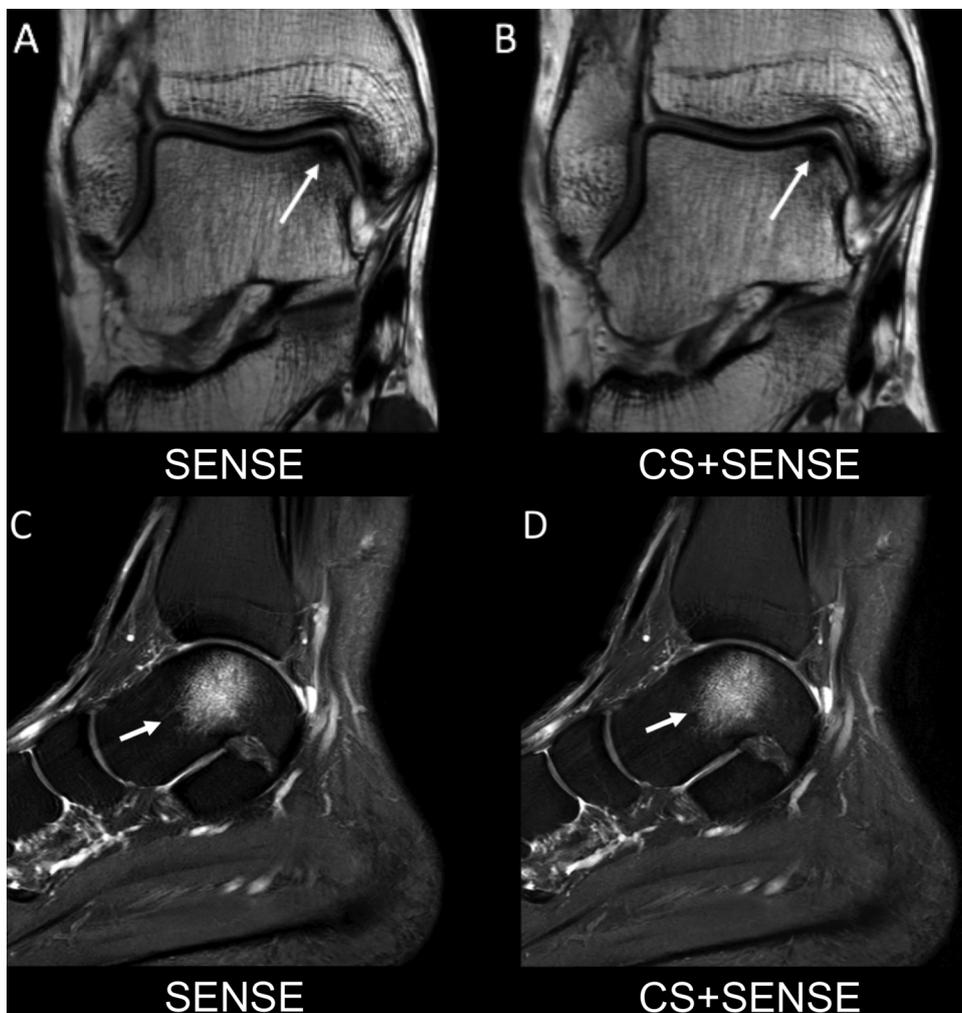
Coronal T1-weighted images acquired using SENSE only (A) and using the combination of CS and SENSE (CS + SENSE; B) showing the ankle of a 42-year-old male volunteer with an osteochondral lesion (long white arrows). Sagittal IM-weighted images with fat saturation acquired with SENSE only (C) and using the combination of CS and SENSE (CS + SENSE; D) depicting bone marrow changes adjacent to the osteochondral lesion (short white arrows). The quality of the depiction of these findings was rated equally for the images acquired with SENSE only and with the combination of CS and SENSE.
